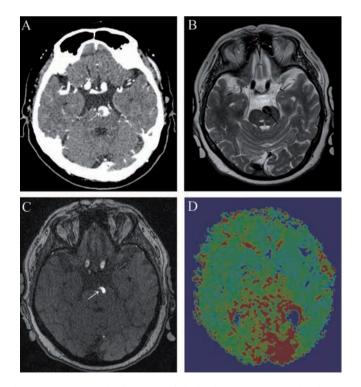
(A) Brain-CT showing the aneurysmatic dilatation of the basilar artery and an inlying thrombus (white arrow); (B) Axial T2-weighted brain-MRI revealing a dolichoectatic and tortuous basilar artery with dissection flap (black arrow); (C) Time of flight MR angiography demonstrating the thrombus (white arrow); (D) Prolonged occipital mean transit time in perfusion MRI.
